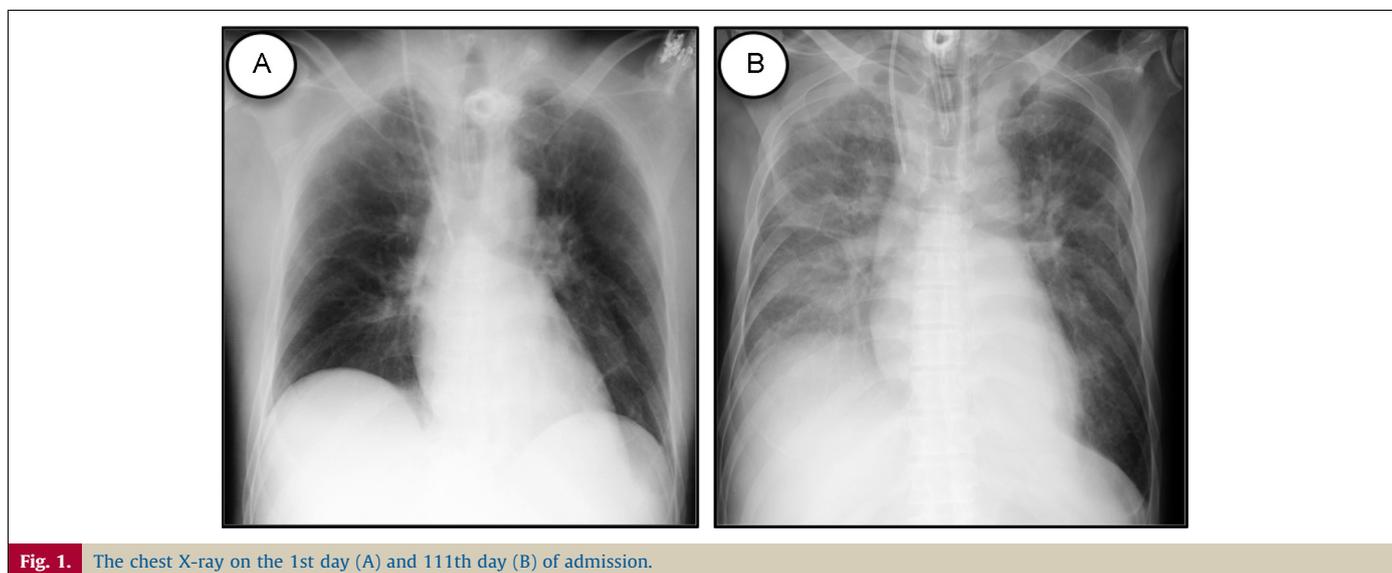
The chest X-ray on the 1st day (A) and 111th day (B) of admission.
